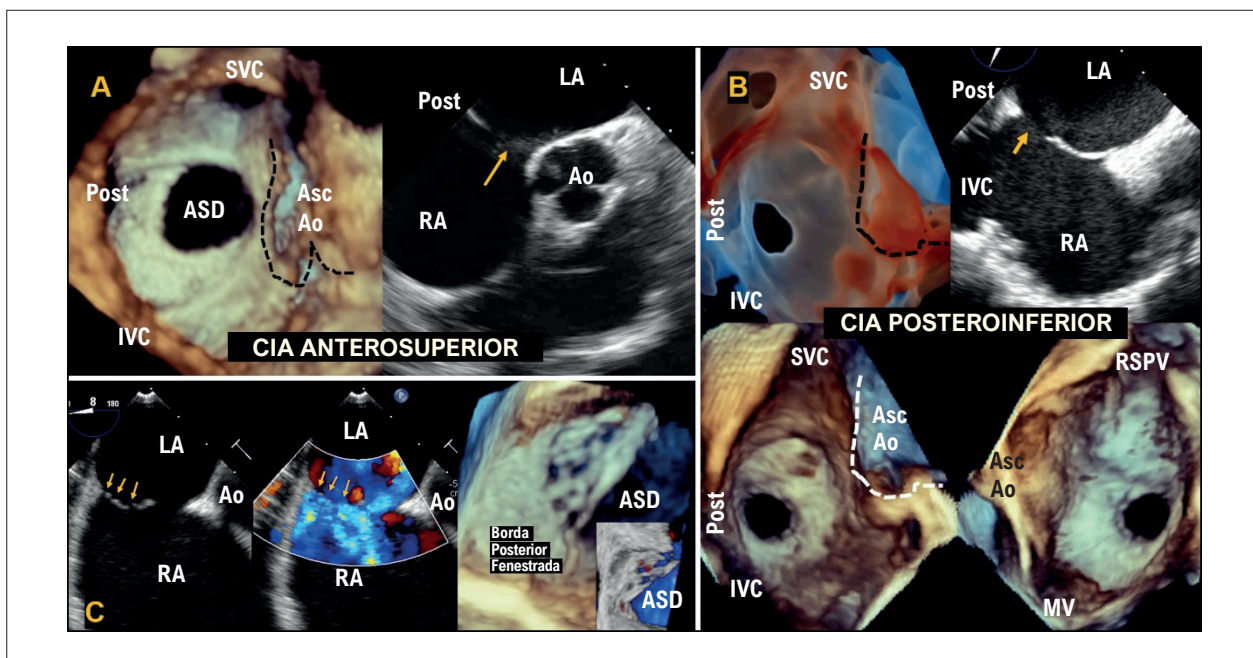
Examples of TEE images of ostium secundum ASDs. A) ASD located in the anterosuperior region of the IAS, visualized by 3D TEE from the RA perspective and by 2D TEE (arrow); B) ASD located in the posteroinferior region of the IAS, demonstrated by 3D TEE from multiple perspectives and by 2D TEE (arrow); C) Image of the posterior rim showing multiple small fenestrations, observed on 2D TEE and with greater detail on 3D TEE. Ao: aorta; ASD: atrial septal defect; IAS: interatrial septum; IVC: inferior vena cava; LA: left atrium; Post: posterior; RSPV: right superior pulmonary vein; SVC: superior vena cava; TEE: transesophageal echocardiography.
